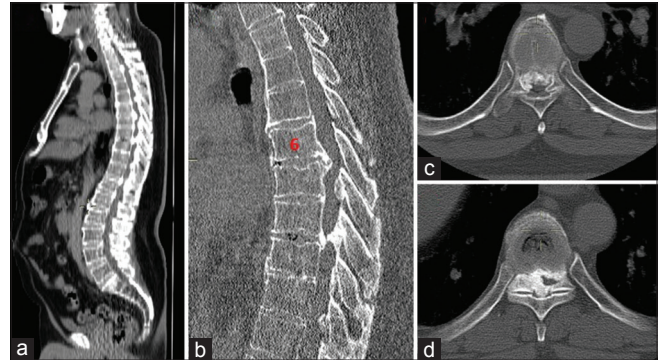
a and b: Sagittal (detailed) CT image demonstrating calcified herniated discs and diffuse ossification over larger parts of the spinal column. c and d: detailed axial CT image at the T6-7 and T8-9 levels showing ossification of the posterior longitudinal ligament, ligamentum flavum and facet joint with subsequent severe spinal stenosis
